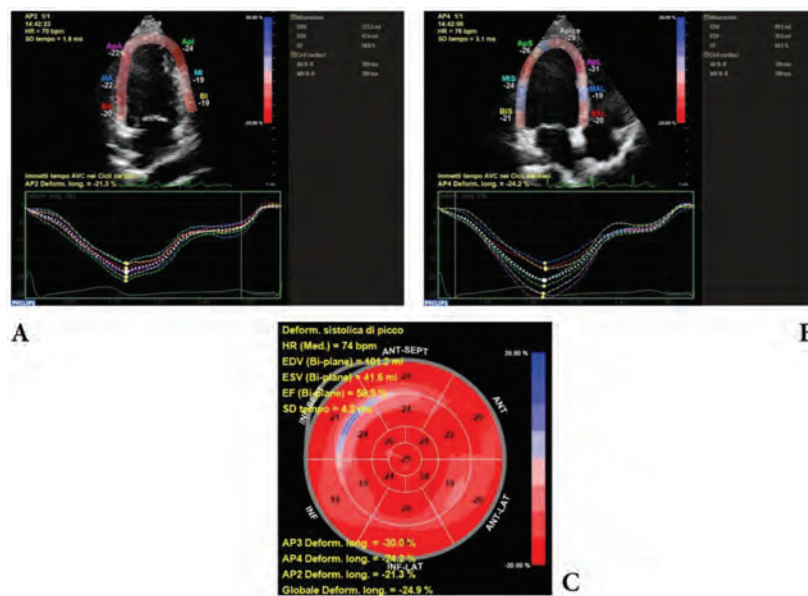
Global longitudinal strain calculation: on top showing tracking in four- (B) and two- (A) chamber view with strain curves; final bull's-eye plot (C) showing global results and superimposed regional values (Normal subject). AP2: apical two-chamber view; AP3: apical three-chamber view; AP4: apical four-chamber view; Deform. Long.: longitudinal deformation; EDV (bi-plane): end-diastolic volume (bi-plane); ESV (bi-plane): end-systolic volume (bi-plane); EF (bi-plane): ejection fraction (bi-plane); global Deform. Long. (GLS): global longitudinal strain; HR: heart rate.
